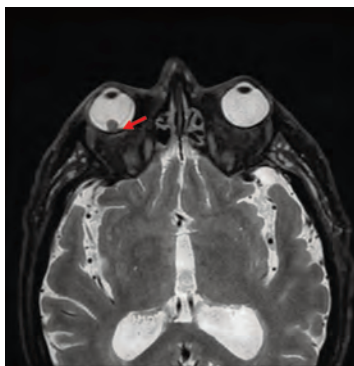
T2 MRI suggesting extrascleral extension of the choroidal mass (arrow).
